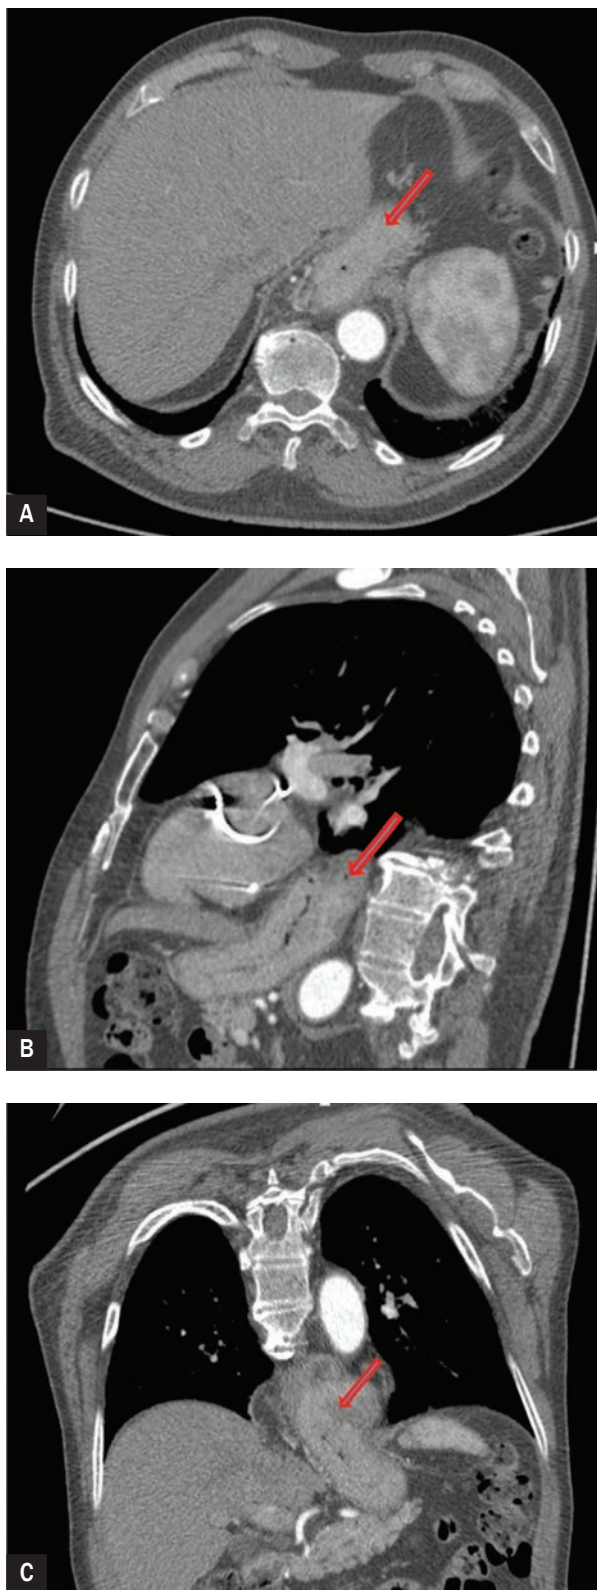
Chest computed tomography – diaphragmatic hiatal hernia marked with an arrow: A. Transverse section (cross-section); B. Sagittal section; C. Coronal section
